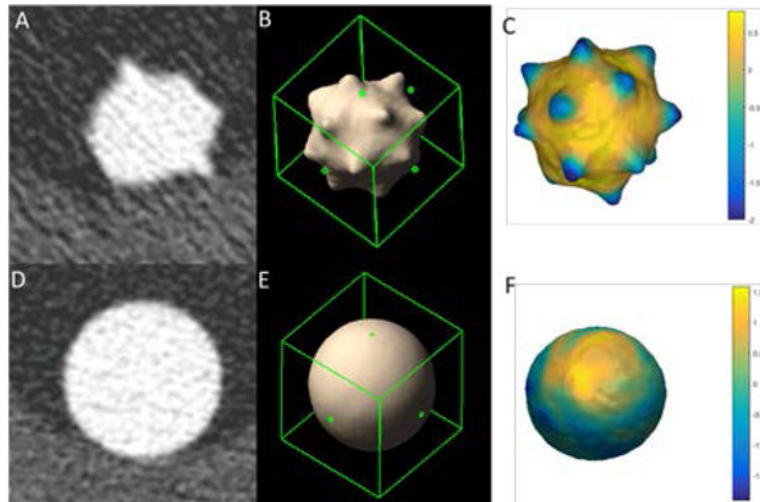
Representative UHR mode axial CT image (A: Star, D: Sphere), 3D volume rendering (B: Star, E: Sphere) and surface curvature distribution (C: Star, F: Sphere) of a star nodule; W/L = 1500/-600 HU
